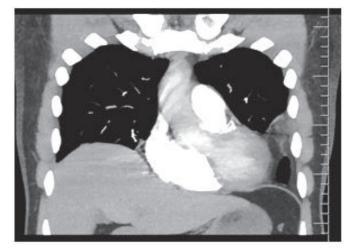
C - CT chest – mediastinal window showing pericardial fat stranding extending up to the costal pleura
